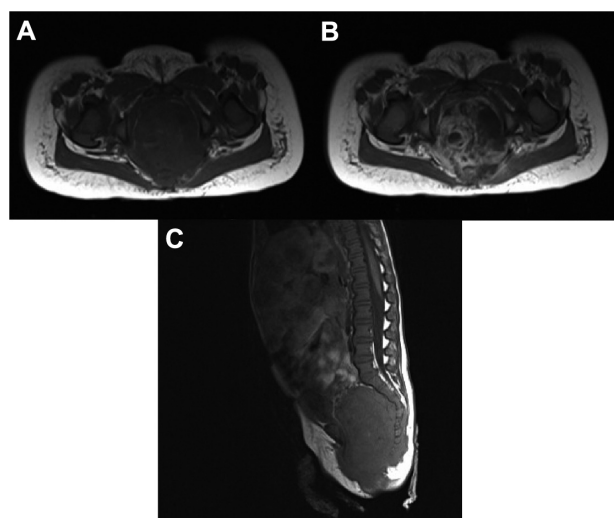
Twenty-month-old female was found to have a pelvic mass on ultrasound (Case 48). A pelvic MRI shows a heterogeneous pre-sacral mass with extension into the spinal canal (A). The mass shows diffuse enhancement, demonstrating extension of the mass through the left sacrosiatic notch into the left gluteal region (B). This malignant sacro-coccygeal teratoma was also noted to have liver metastases (C).
